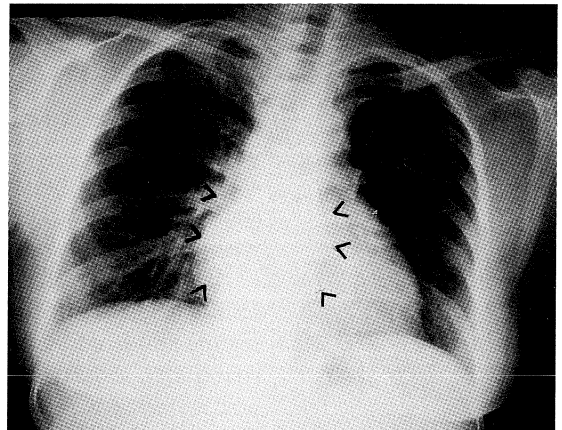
Chest radiograph, postero-anterior view: the lung fields are clear. However, there are para-vertebral soft-tissue shadows (arrowed) at the level of the lower thoracic vertebrae.
